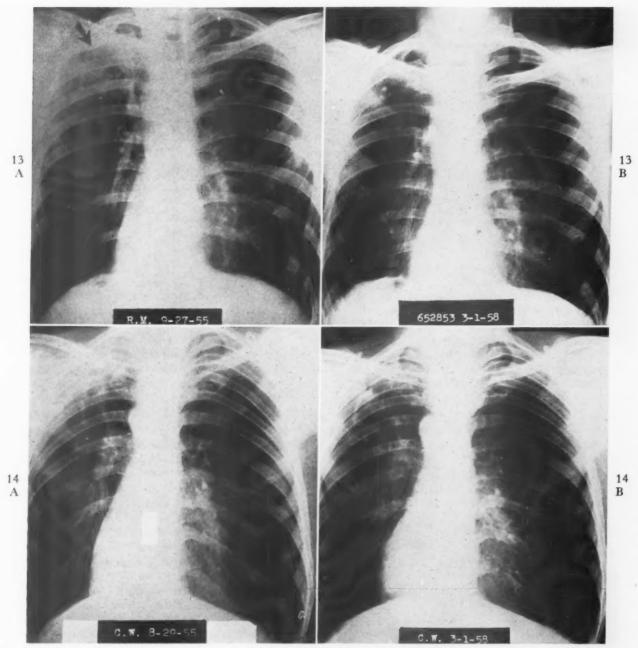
Case IX. Chest roentgenograms; A, approximately eight months before left apical posterior segmental resection showing character of left cavitary lesion. B, twenty-two months after operation. There is no recurrence of the lesion; slight scarring is noted at the site of resection.
